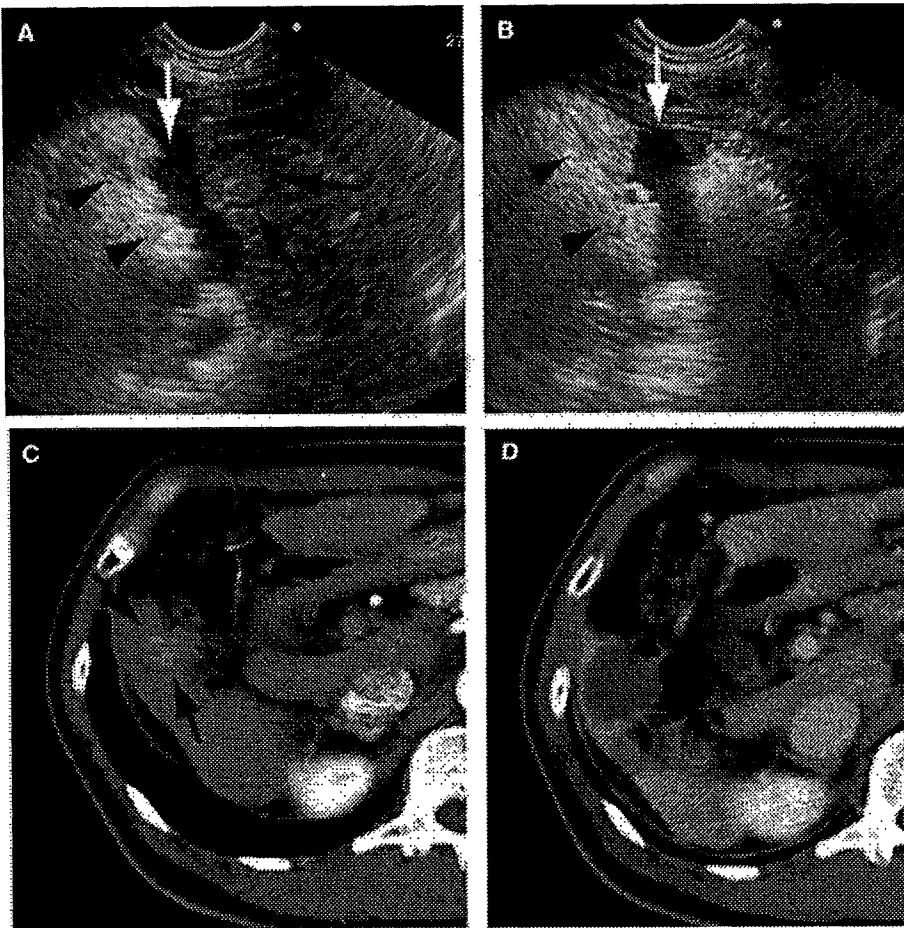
Percutaneous radiofrequency ablation with artificial ascites. (a) After injection of 5% glucose (white arrow), tumor (black arrows) was separated from the colon (black arrowheads). (b) After ablation, a hyperechoic area (black arrow) appeared. (c) Computed tomography revealed a tumor (black arrows) close to the colon. (d) Tumor was completely ablated.
